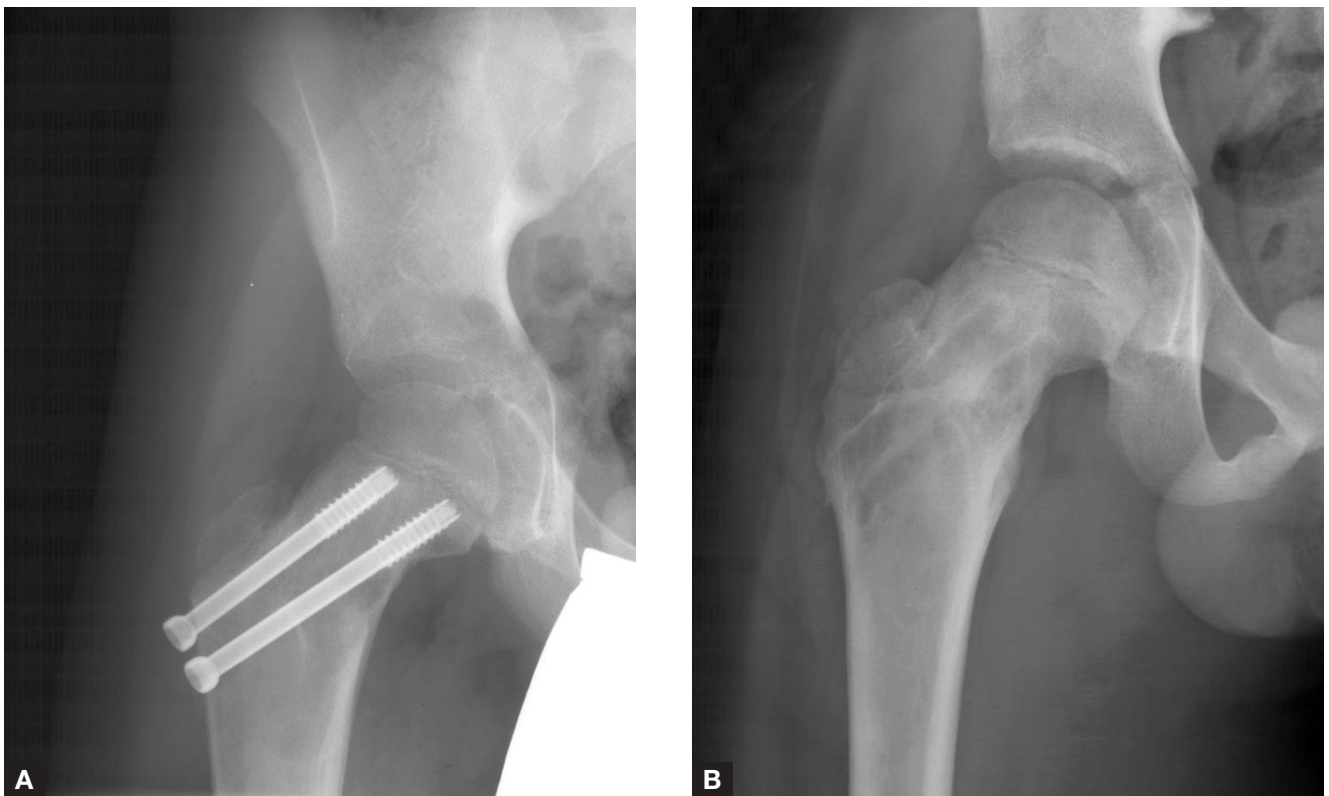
(A) Immediate postoperative radiographs show treatment with screw fixation and open bone grafting of lesion. (B) The patient had normal hip motion and no pain 2 years after hardware removal.
